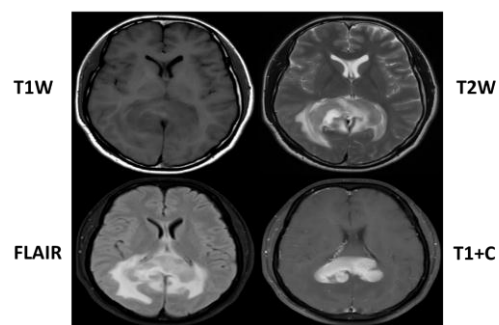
An axial T1W and T2 weighted MR images shows the splenic lesion appearing isointense with respect to gray matter. Bilateral parietal edema is T2W/FLAIR hyperintense. An axial T1W+C MR image after contrast shows homogenous intense enhancement
